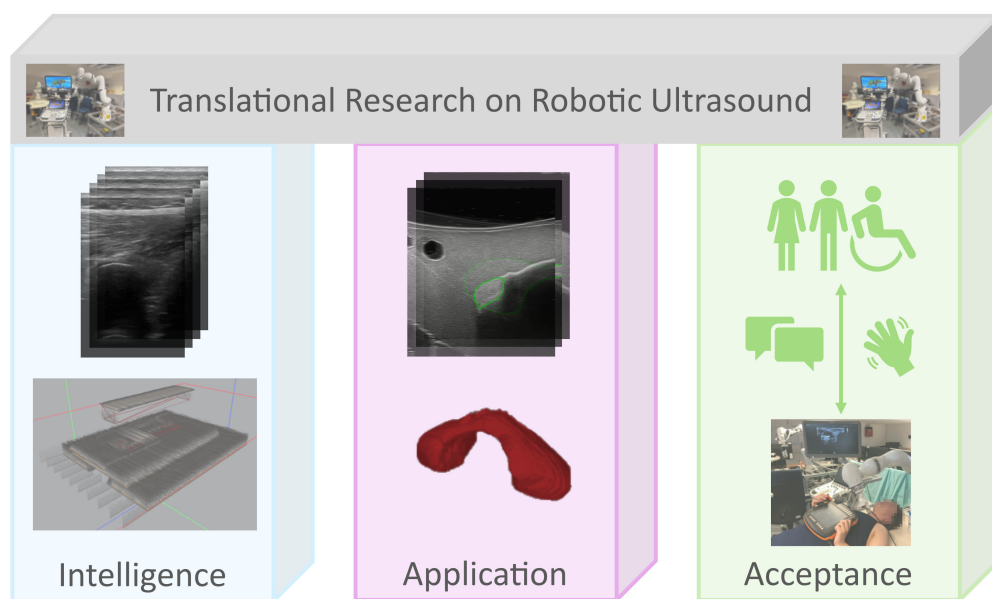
The three pillars, intelligence, application, and acceptance, required for successful translation research on robotic ultrasound, filled with proposed methods to enable and enhance all three research topics.
